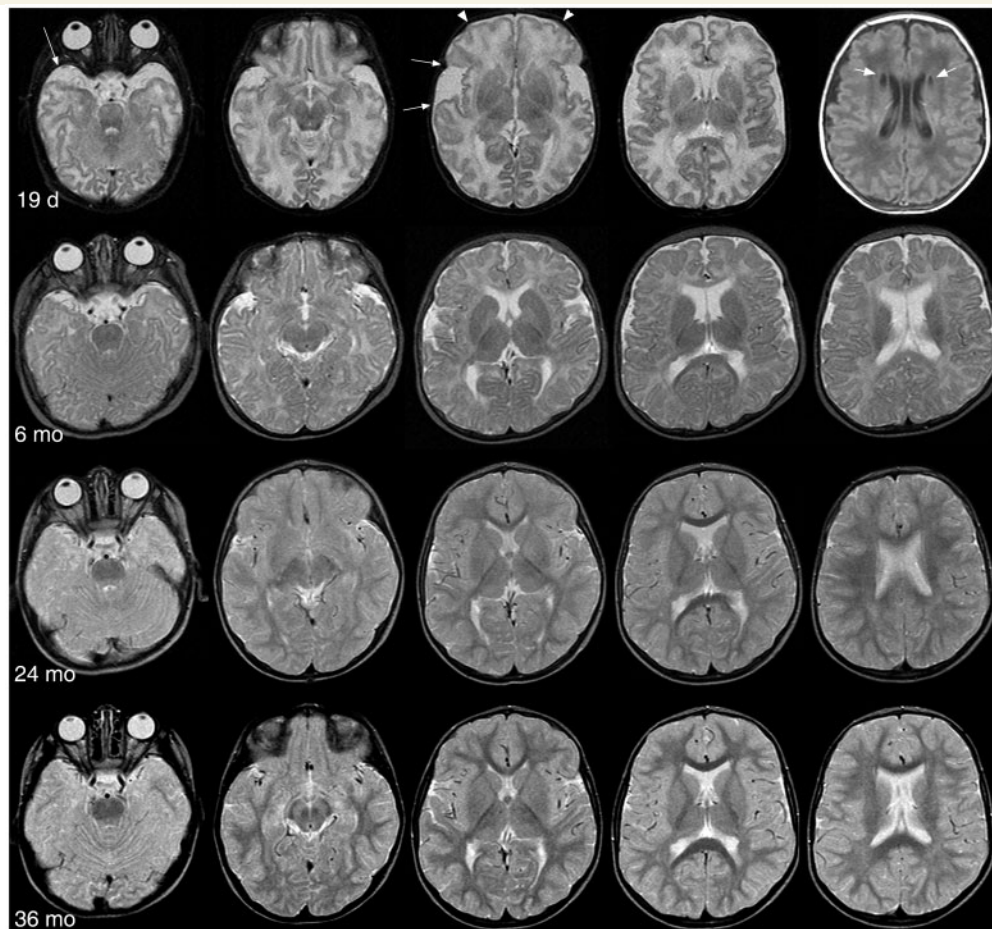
Sequential MRIs of Case 3 (Patient #37) between the ages of 19 days and 36 months (T_2 -weighted images, except for fluid attenuated inversion recovery images, right upper corner). MRIs document normalization of frontotemporal hypoplasia (unilateral long arrows) and disappearance of subependymal pseudocysts (short arrows) and cavum vergae. The term newborn has an immature pattern of gyration and myelination normally observed at 34–35 weeks postconceptional age with too shallow and less branched sulci (arrowheads) and slightly, diffusely T_2 hyperintense white matter. The adult gyral pattern is normally reached by 3 months, and on follow-up MRI gyration is adequate for age. Myelination at 24 months is still insufficient in the subcortical temporal and frontal white matter, but at 36 months myelination is complete and the MRI is now normal.
